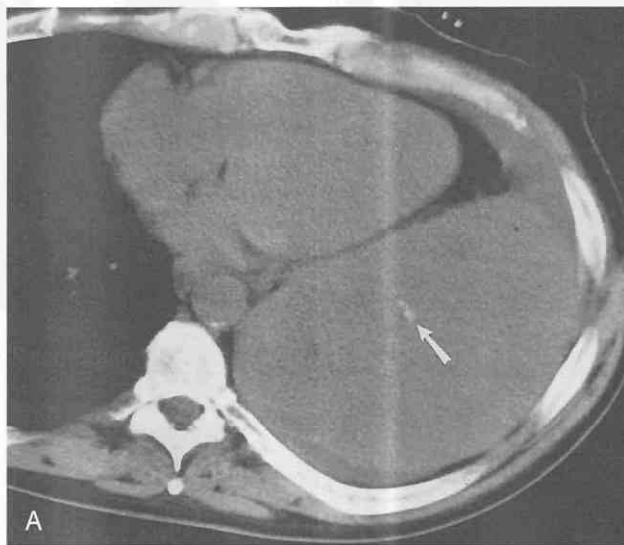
Synovial carcinoma of left lung seen as a large mass. *A*, CT shows a large mass in the left lower lobe with a small focal calcification (*arrow*). A small pleural effusion can be seen. *B* and *C*, Coronal T1-weighted (*B*) and fast spin-echo (*C*) MR images show a large heterogeneous mass abutting the diaphragm without signs of invasion. A small pleural effusion (*P*) can be seen. *L*, liver; *M*, mass.
